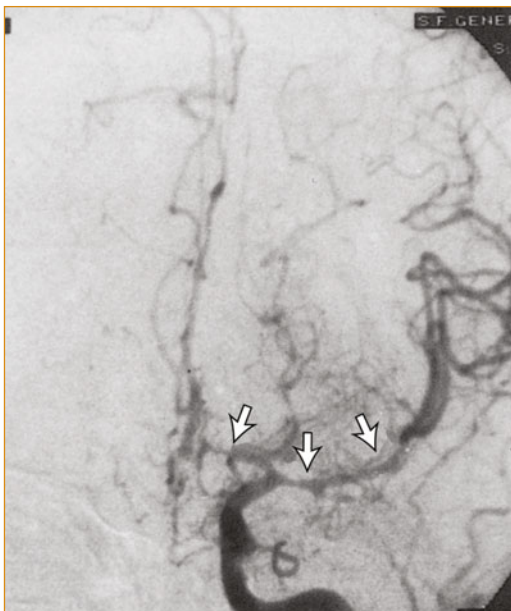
Anteroposterior view, left carotid angiogram, of a 26-year-old man with meningovascular syphilis, showing constriction (arrows) of the anterior and middle segments of the middle cerebral artery. Cerebrovascular syphilis occurs when the inflammation in the subarachnoid space compromises arteries traversing this space. Vasculitis of middle-sized vessels occurs, resulting in ischemia. The middle cerebral artery is affected most often, but any cerebral or spinal vessel may be involved. Stroke syndromes occurring in neurosyphilis are no different than those seen from other causes; focal clinical manifestations are determined by which vessel is involved. The patients exhibit risk factors for venereal disease and are usually younger than those with atherosclerotic infarction. Differentiation depends upon the blood and cerebrospinal fluid serologic results. CT or MRI scans of the brain reveal cortical or subcortical infarction. If the meningeal inflammation is intense enough, a prodrome of headache and personality change may precede the stroke by weeks (meningovascular syphilis). Penicillin effectively cures the infection, preventing further infarctions. (From Simon and Bayne [91]; with permission.)
